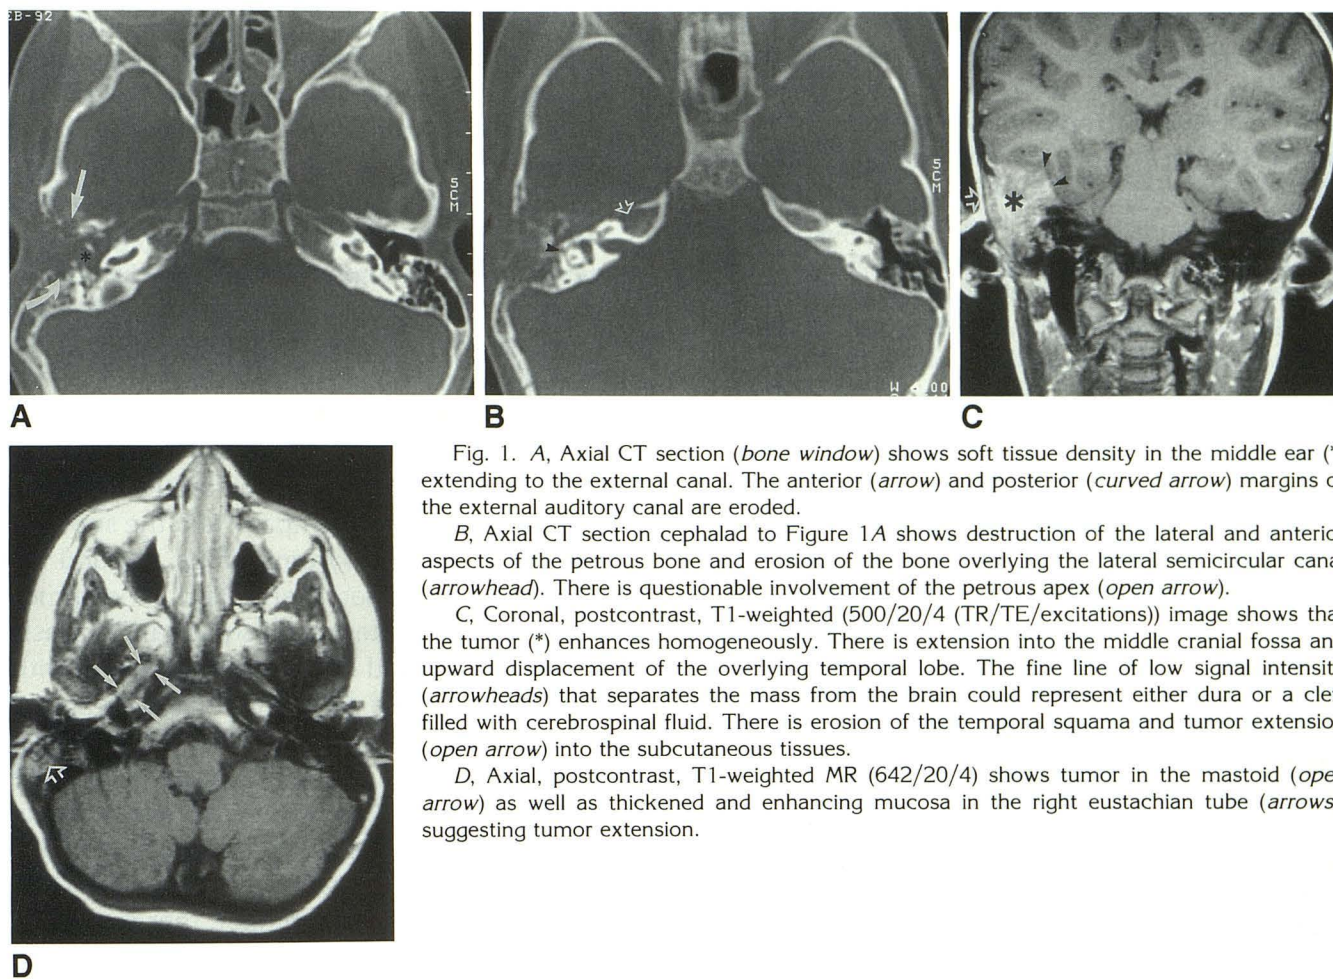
A, Axial CT section (*bone window*) shows soft tissue density in the middle ear (\*) extending to the external canal. The anterior (*arrow*) and posterior (*curved arrow*) margins of the external auditory canal are eroded.
